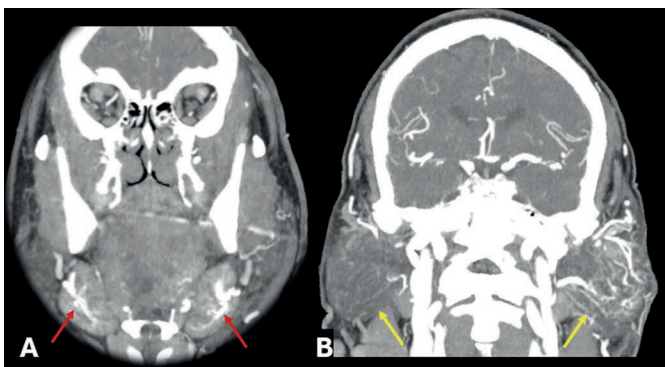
Craniocervical CT angiography (CTA), coronal maximum intensity projection (MIP) images. Marked enlargement with diffuse vascular prominence of the submandibular glands (A, red arrows) and parotid glands (B, yellow arrow), particularly pronounced in the left parotid gland, with findings consistent with an acute inflammatory process.
